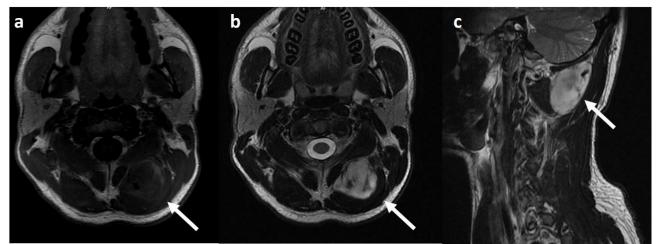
Magnetic resonance imaging view of spindle cell lipoma. T1 axial (a), T2 axial (b), and sagittal view (c) demonstrated well-defined calcific lesions (white arrow)
